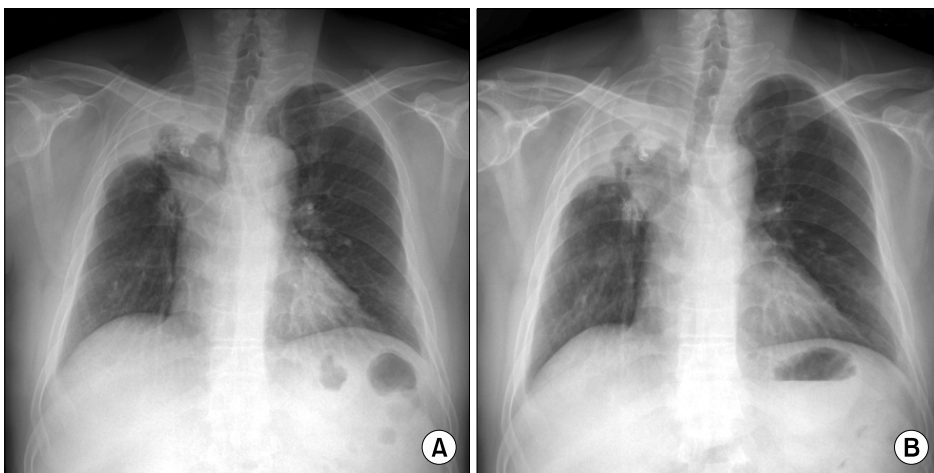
(A) Chest X-ray at discharge showed inserted coils into bronchopleural fistula and small amount of dead space and moderate pleural thickenings. (B) At 9 months postoperatively, chest x-ray revealed decreased pleural thickenings and well anchored coils in the bronchopleural fistula tract.
